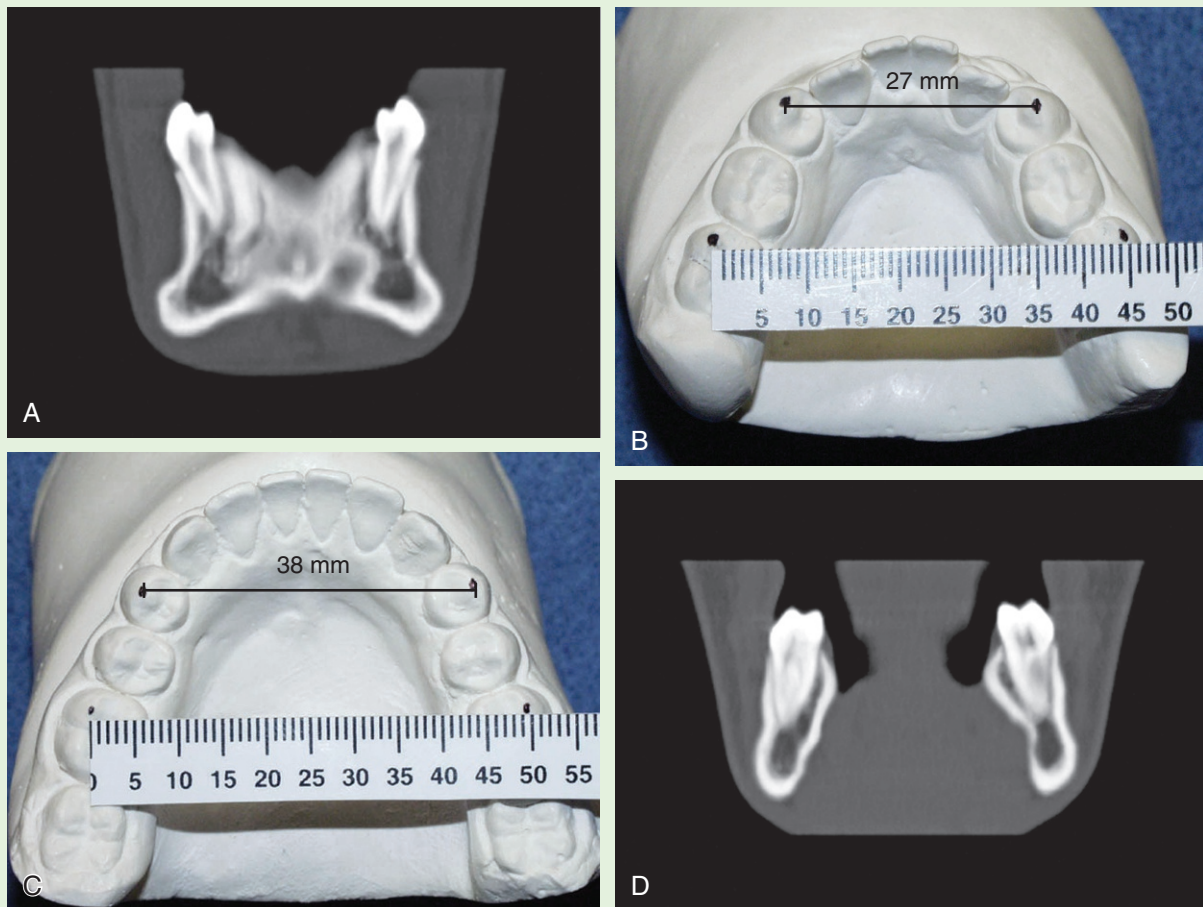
Comparisons of pretreatment and posttreatment lower arch plaster models for CB with computed tomographic scans. Pretreatment and posttreatment models of lower arch show 11-mm change in first premolar width and 5-mm change in first molar width. Vertical scans, taken 5 years, 3 months into retention, show healthy alveolar bone. A, Scan of lower first premolars 5 years, 3 months in retention. B, Pretreatment. First premolars: 27 mm; first molars: 44.5 mm. C, Posttreatment. First premolars: 38 mm; first molars: 49.5 mm. D, Scan of lower first molars 5 years and 3 months in retention.
